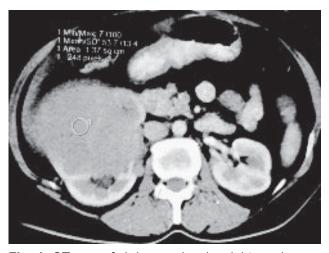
CT scan of abdomen showing right renal mass.
